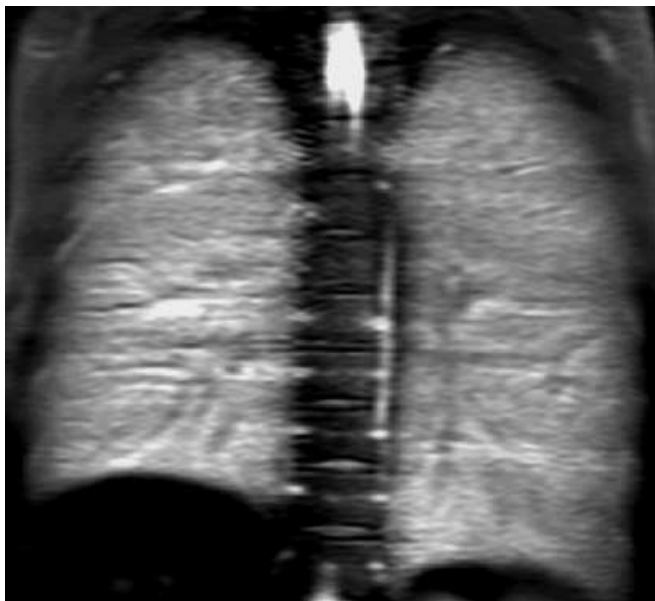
Hydrogen-1 MRI with oxygen enhancement in a healthy volunteer showing homogeneous ventilation and enhancement of pulmonary veins reflecting the distribution of dissolved molecular oxygen
